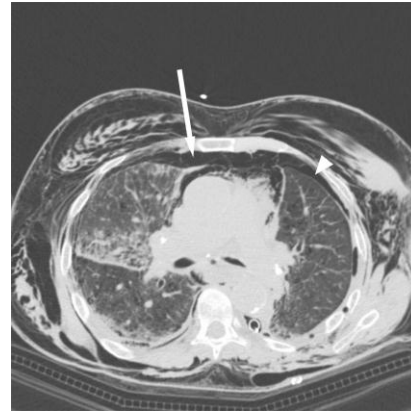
CT scan. Patient with inferior left lobectomy for lung cancer with pneumomediastinum and massive subcutaneous emphysema. CT scan shows left pneumothorax (arrowhead).
